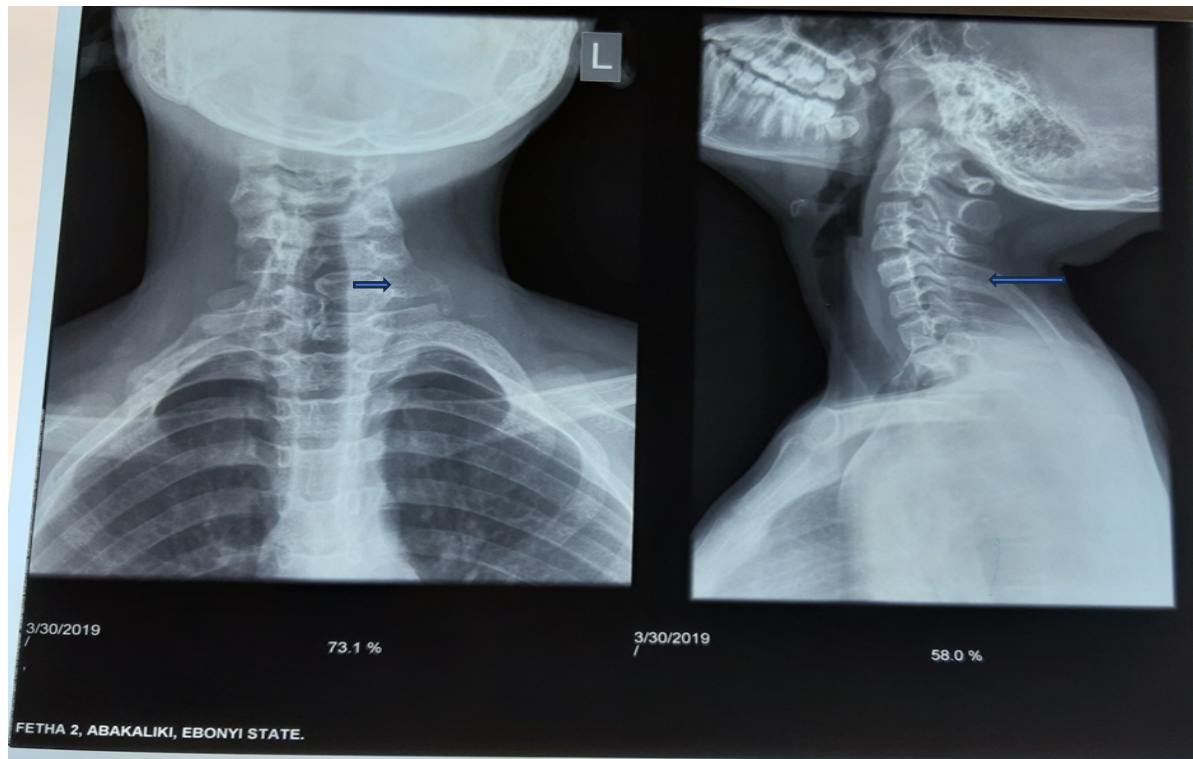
plain radiographs of the cervical spine (AP & Lateral) showing a giant spinous process of C5 curving downwards with well-defined medulla and cortical outlines (long horizontal white arrow). The AP radiograph shows subtle abnormal curvature towards the right with hemivertebra at C6 level (black arrowhead) and osteophytic bridging of C6/7 transverse processes (short white arrow).
